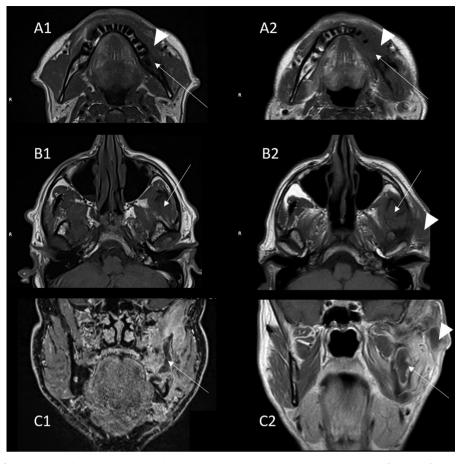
Left column shows the first MRI, right column shows the second MRI 6 months later. First row (A1 and A2) shows the infiltration of the mandible as a decrease of the T1 signal (thin arrow), more expanded on the second MRI (A2); soft tissue infiltration (arrowhead) is also more pronounced on the 2nd MRI. Second row shows the infiltration of the temporal muscle (thin arrow), and appearance on the 2nd MRI of a temporal subcutaneous mass (arrowhead). Last row (C1 coronal T1 after injection and Fat saturation, C2 coronal T1 after injection) shows the necrotic mass in the coronoid process (thin arrow) and appearance on the 2nd MRI of a temporal subcutaneous mass (arrowhead). MRI performed at 6 months. The coronal view, weighted in T2 shows spread of the abscess to the temporal fossa, lysis and signs of inflammation in the jaw muscles and mandibular bone marrow with large collections involving the temporal fossa (black arrows).
